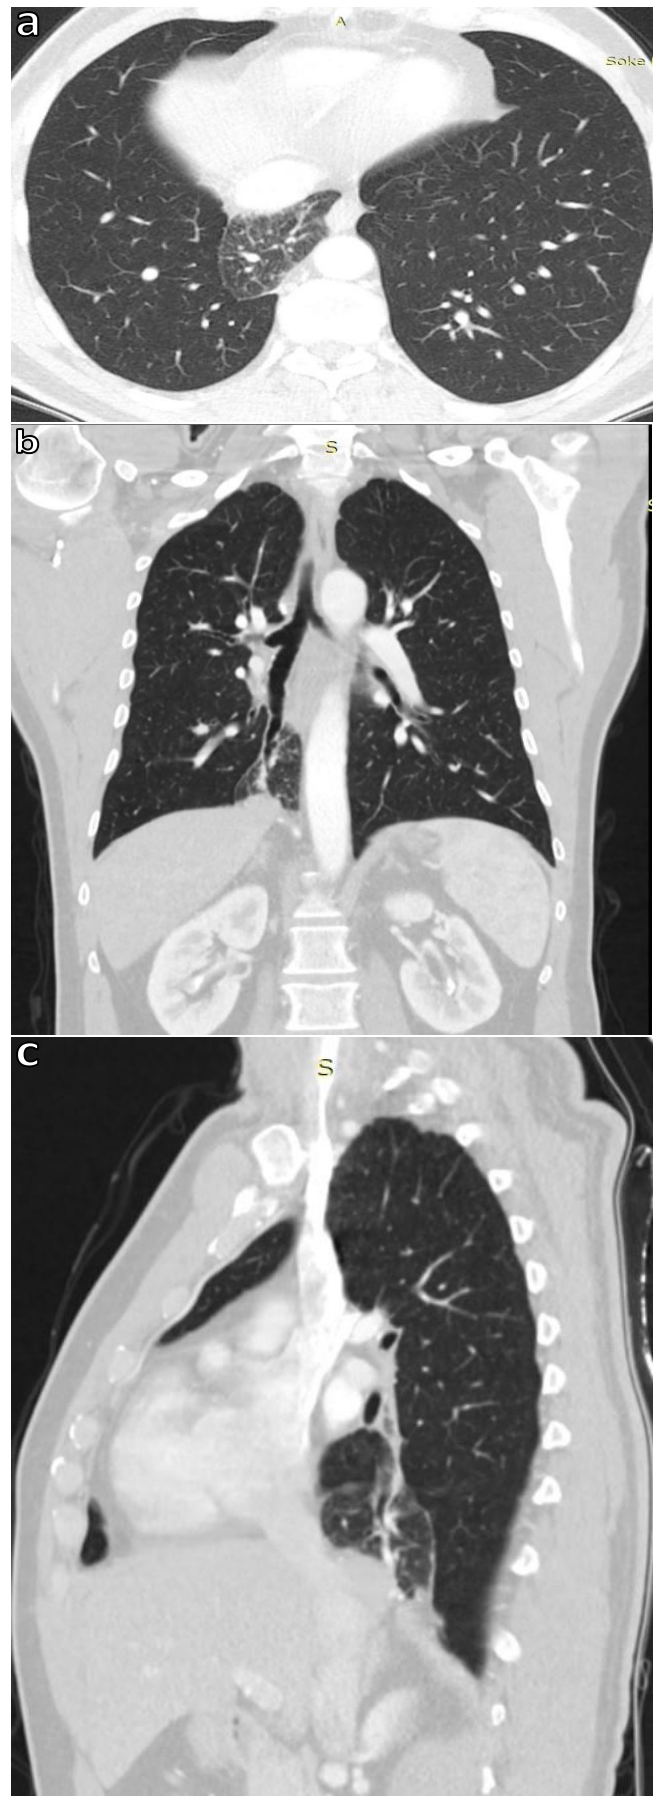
Views of right lower lobe ELS on thoracic CT image; axial (a), (b) and sagittal (c)
